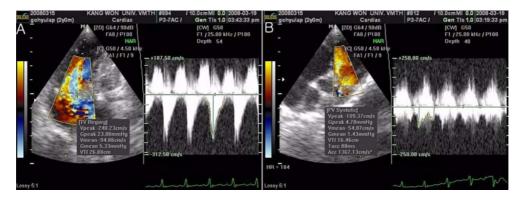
Color spectral Doppler echocardiography of this case. A: Echocardiogram taken at tricuspid valvular area moderate tricuspid turbulent regurgitant flow with a peak velocity of 2.4 m/sec (pressure gradient between right ventricle (RV) to right atrium; 23 mmHg) at systole. B: Echocardiogram taken at pulmonic valvular area mild pulmonary turbulent regurgitant flow with a peak velocity of 1.1 m/sec (pressure gradient between pulmonic artery to RV; 5 mmHg) at systole and diastole.
